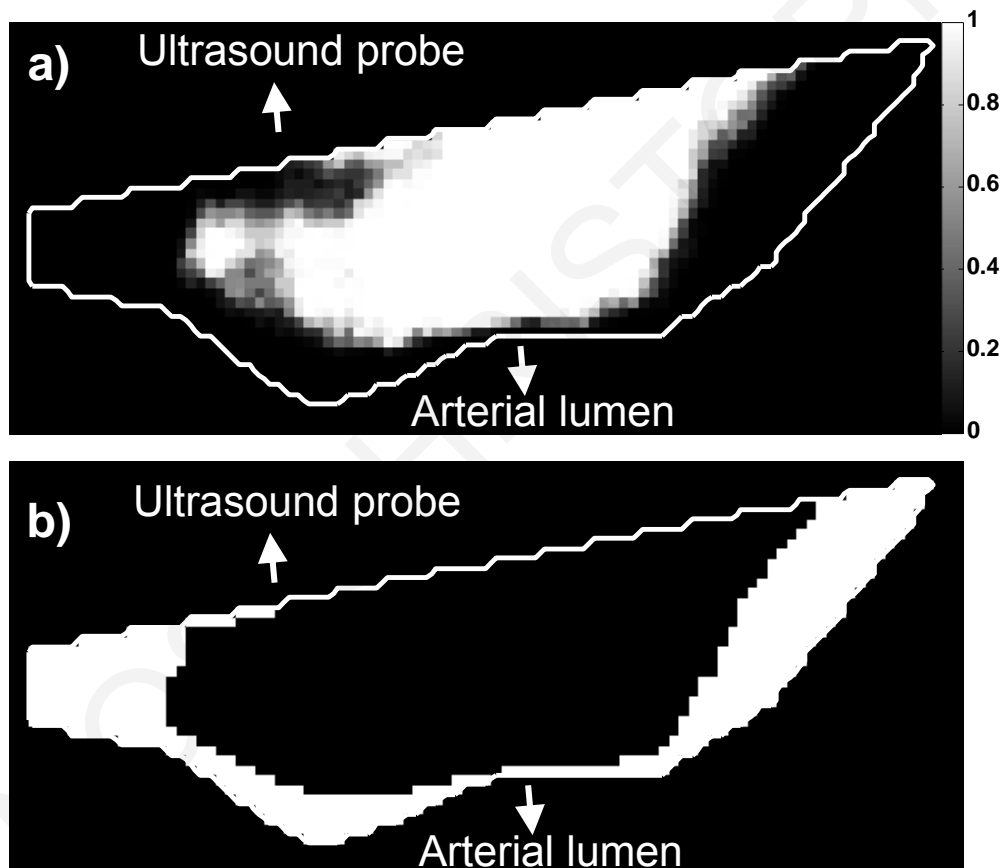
Results of dynamic contrast-enhanced ultrasound (DCEUS) quantification analysis of a near-wall carotid plaque (delineated with white line) from a symptomatic patient. a) Parametric map of p-values from the two sample Kolmogorov-Smirnov test used to detect intraplaque perfusion is shown. b) A threshold of 0.001 is used on the p-value parametric map to differentiate between perfused ($p\text{-value} < 0.001$) and non-perfused pixels ($p\text{-value} \geq 0.001$). In this symptomatic patient the plaque had 32% perfusion coverage.
